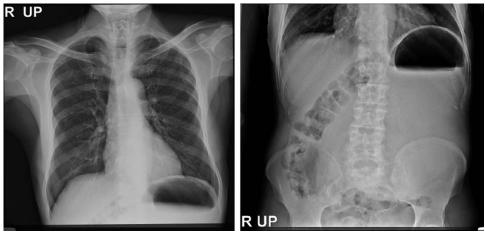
Chest and abdominal radiographs reveal a large suspicious abdominal mass.
